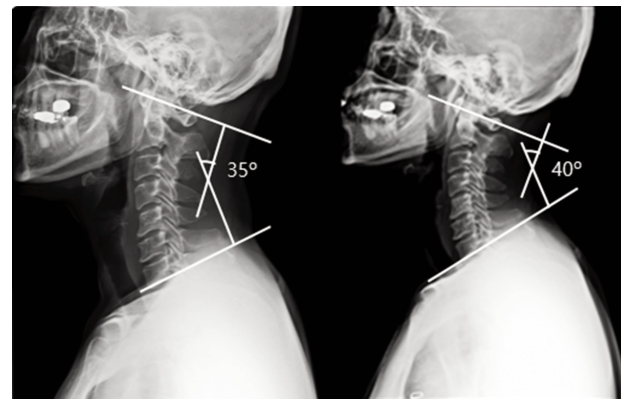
Cervical lordosis on a X-ray (left: before, right: after)
